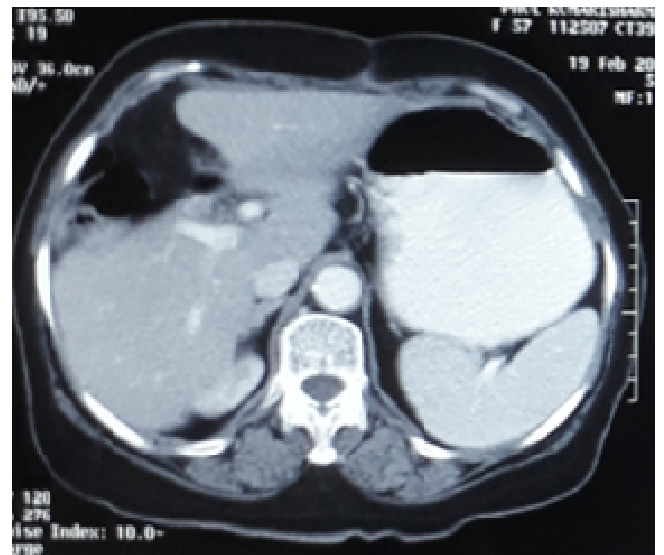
Post cholecystectomy and post adjuvant chemotherapy CT scan
